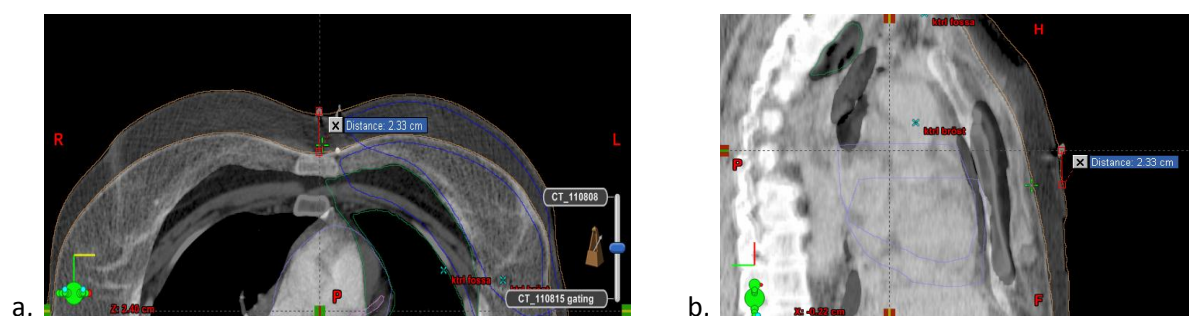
Measurement of the movement of the radioopaque marker using the rigid registered CT-images in the vertical direction (a) and the longitudinal direction (b)
